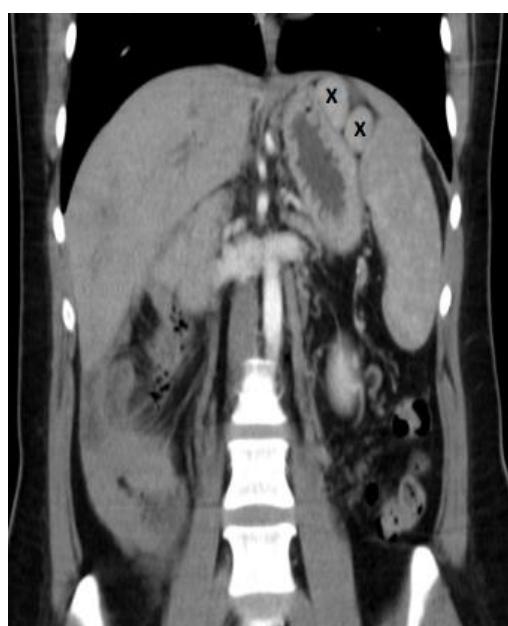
Contrast abdominal CT (arterial phase), coronal section, showing splenomegaly and the presence of two accessory spleens (X) of 21 and 25 mm diameter (polysplenia).
